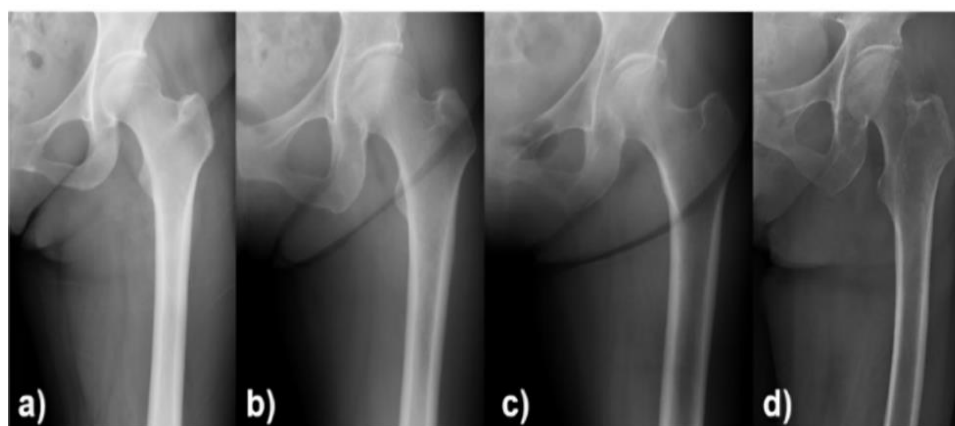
Four X-ray examples that are used to categorize the risk of osteoporosis, 15 surgeons for these cases were a: very unlikely, b: unlikely, c: suspicious, and d: very suspicious [34].
